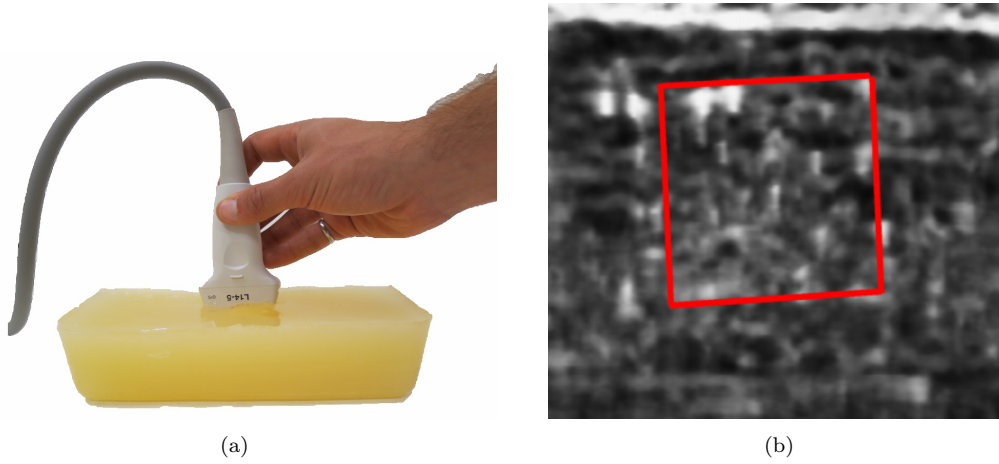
(a) Elastography setup with artificial tissue. The ultrasound transducer is positioned to image the artificial tissue from the top. (b) Elastographic image, with the hard inclusion outlined in red. This outline was obtained by visual inspection of the image and manual selection of the corners of the inclusion. From this user-created classification, Gaussian discriminant analysis was applied to develop a classifier that would sort new data points into one of the two classes. The classifier was then mapped from sorting elastography data to sorting absolute stiffness data, and provided the initializing classifier for the EM algorithm.
